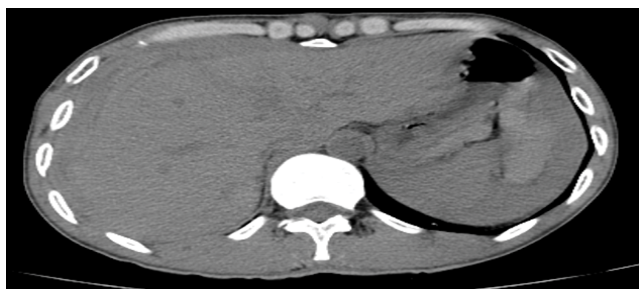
Immediate CT scan showed liver laceration and sub-capsular hematoma.
